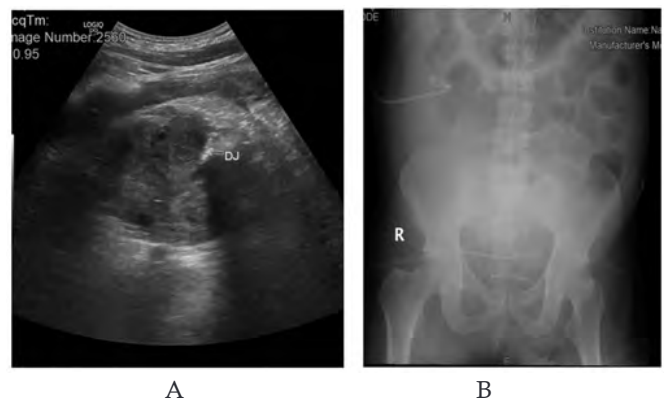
Postoperative ultrasound showing no residual stone. 4B. Postoperative KUB showing the indwelling ureteral stent in the ectopic kidney.
